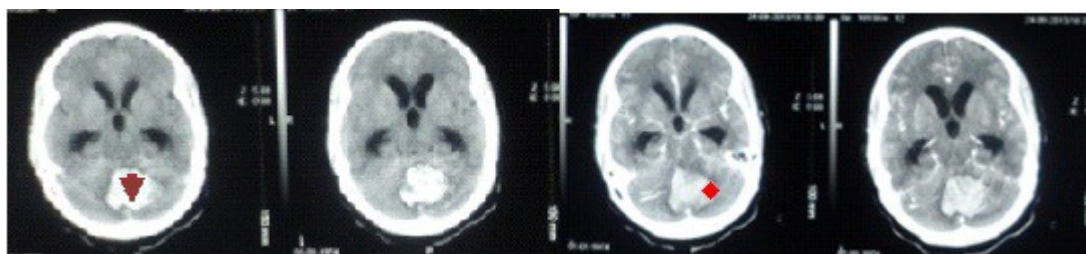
Pre- and post-contrast computed tomography (CT) showing a well circumscribed, hemorrhagic lesion in the posterior fossa (arrow head) with minimal perilesional oedema and mild contrast enhancement (star). There is associated third and lateral ventriculomegaly
